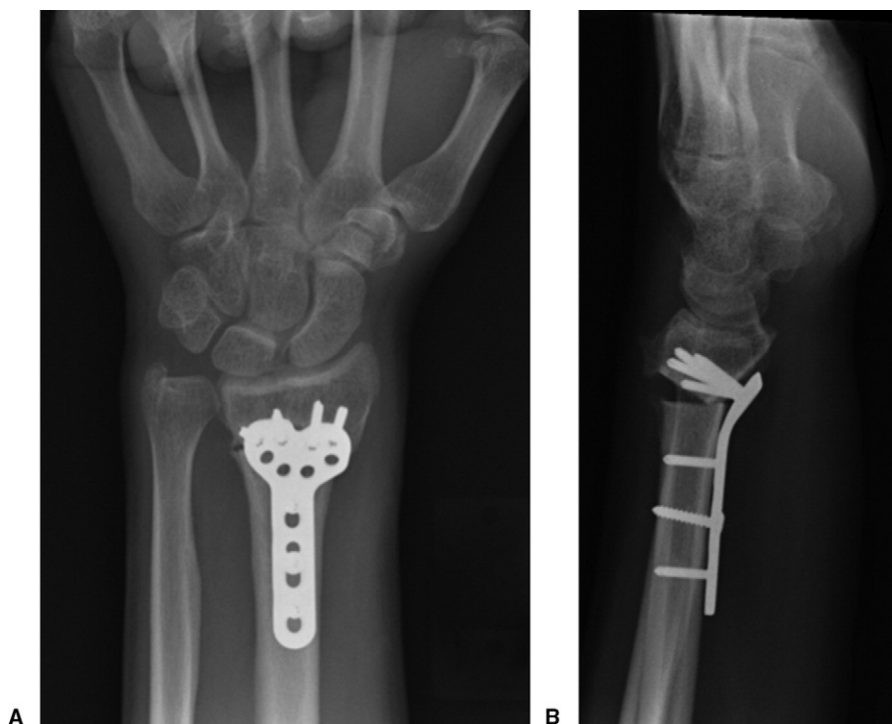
The patient had corrective osteotomy and volar plating without bone graft. A Anteroposterior and B lateral radiographs show the postoperative view after 4 weeks.
